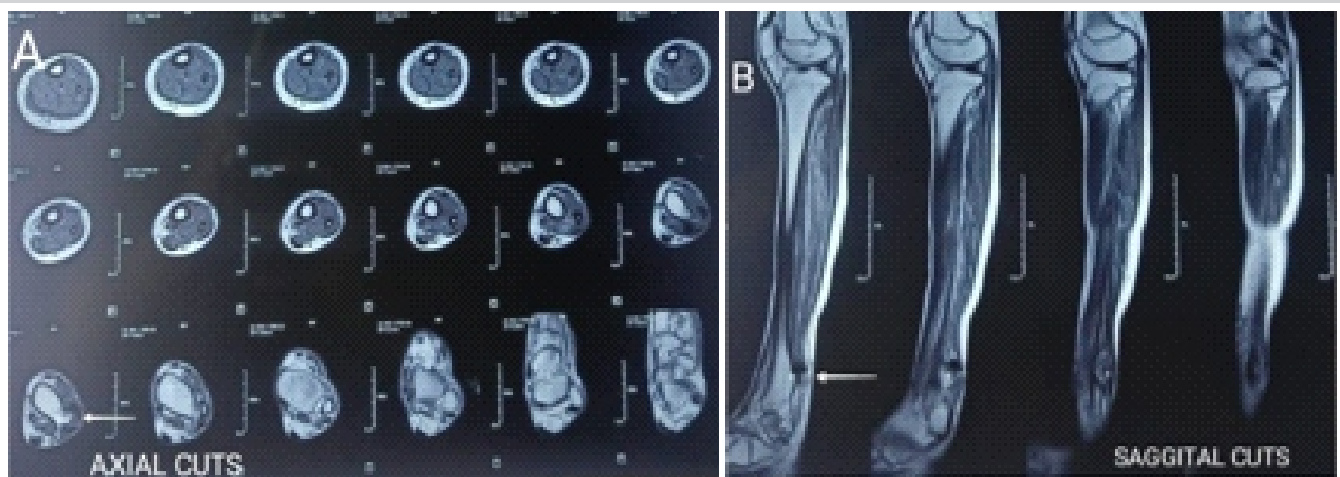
MRI leg with ankle joint (A) Axial cuts (B) Sagittal cuts – showing solitary osteochondroma of the outer margin of lower tibial metaphysis as broad stalk exostosis with continuity of bone cortex and medullary marrow space to the host bone.
